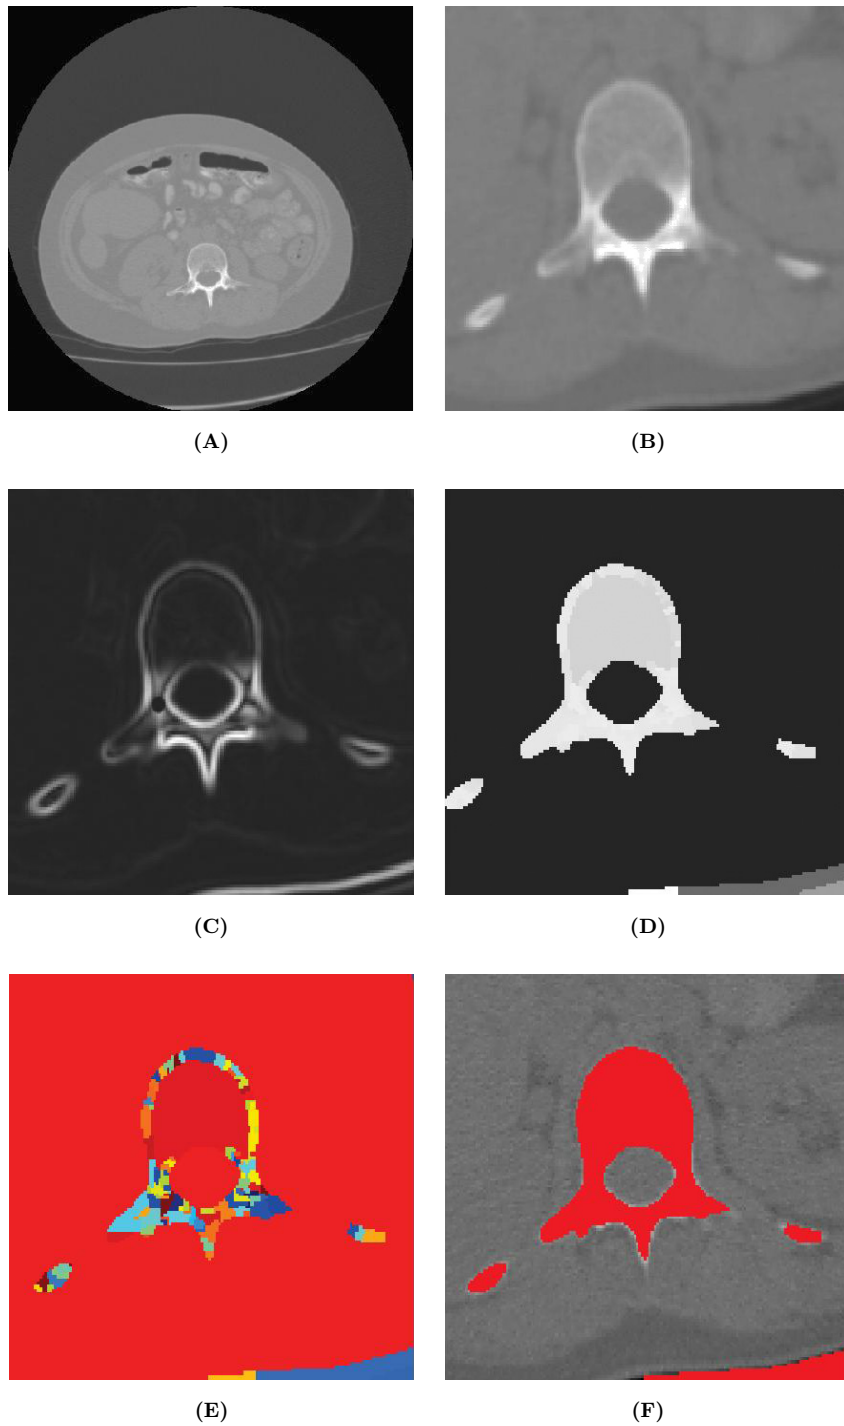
Preprocessing and segmentation of CT images. (A) CT Axial slice view. (B) ROI with noise reduction through the anisotropic diffusion filter. (C) Image gradient module of B. (D) Watershed segmentation applied to border image C. (E) Watershed image view on color map. (F) Spine zone selection through threshold technique.
